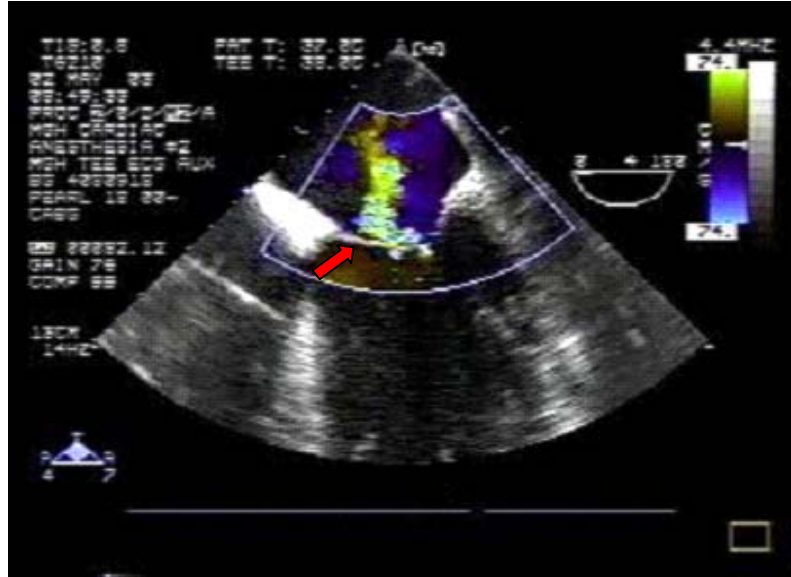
Color doppler image of patient with ischemic mitral regurgitation. The red arrow shows a tethered anterior leaflet in the area of strut chord insertion. This tethering results in regurgitation jets as shown by the yellow retrograde flow.
